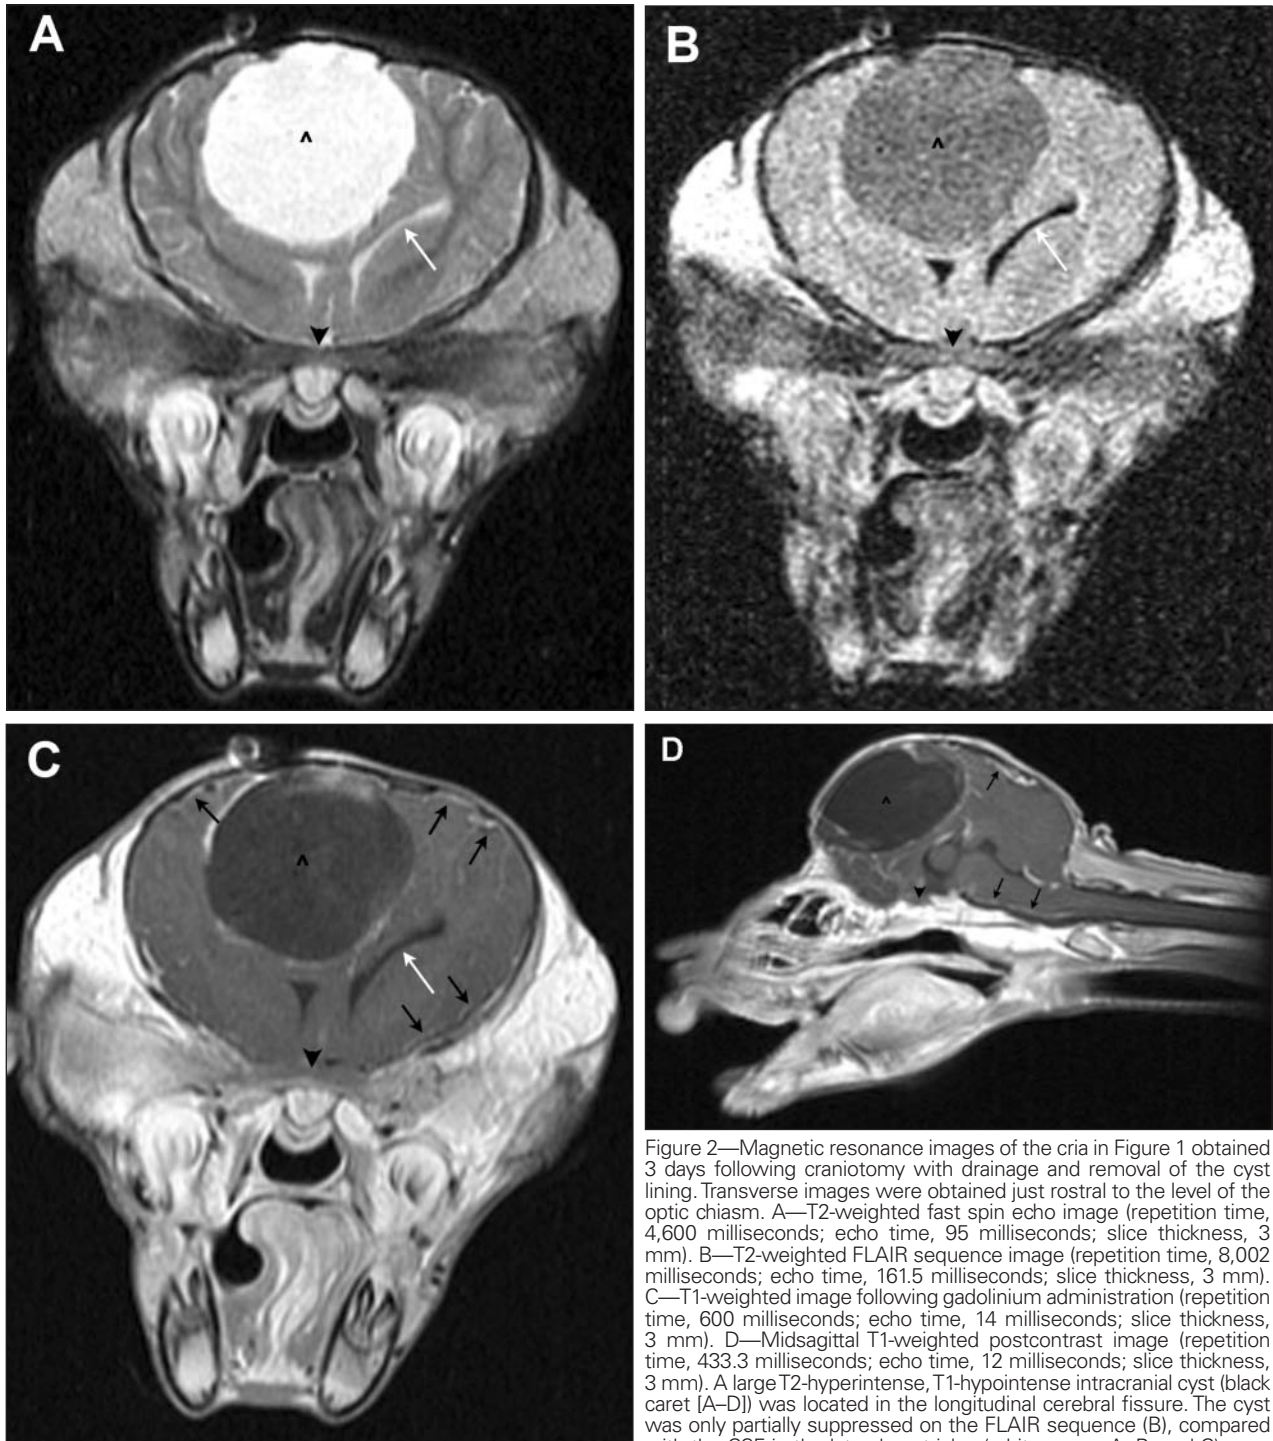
Magnetic resonance images of the cranium in Figure 1 obtained 3 days following craniotomy with drainage and removal of the cyst lining. Transverse images were obtained just rostral to the level of the optic chiasm. A—T2-weighted fast spin echo image (repetition time, 4,600 milliseconds; echo time, 95 milliseconds; slice thickness, 3 mm). B—T2-weighted FLAIR sequence image (repetition time, 8,002 milliseconds; echo time, 161.5 milliseconds; slice thickness, 3 mm). C—T1-weighted image following gadolinium administration (repetition time, 600 milliseconds; echo time, 14 milliseconds; slice thickness, 3 mm). D—Midsagittal T1-weighted postcontrast image (repetition time, 433.3 milliseconds; echo time, 12 milliseconds; slice thickness, 3 mm). A large T2-hyperintense, T1-hypointense intracranial cyst (black caret [A–D]) was located in the longitudinal cerebral fissure. The cyst was only partially suppressed on the FLAIR sequence (B), compared with the CSF in the lateral ventricles (white arrow; A, B, and C), consistent with the high protein content of the cystic fluid. A decrease in the size of the intracranial cyst is evident, compared with CT images obtained at the same level (A and C). Meningeal enhancement was present on the postcontrast images (black arrows) and likely represents sterile meningitis from previous craniotomy.
